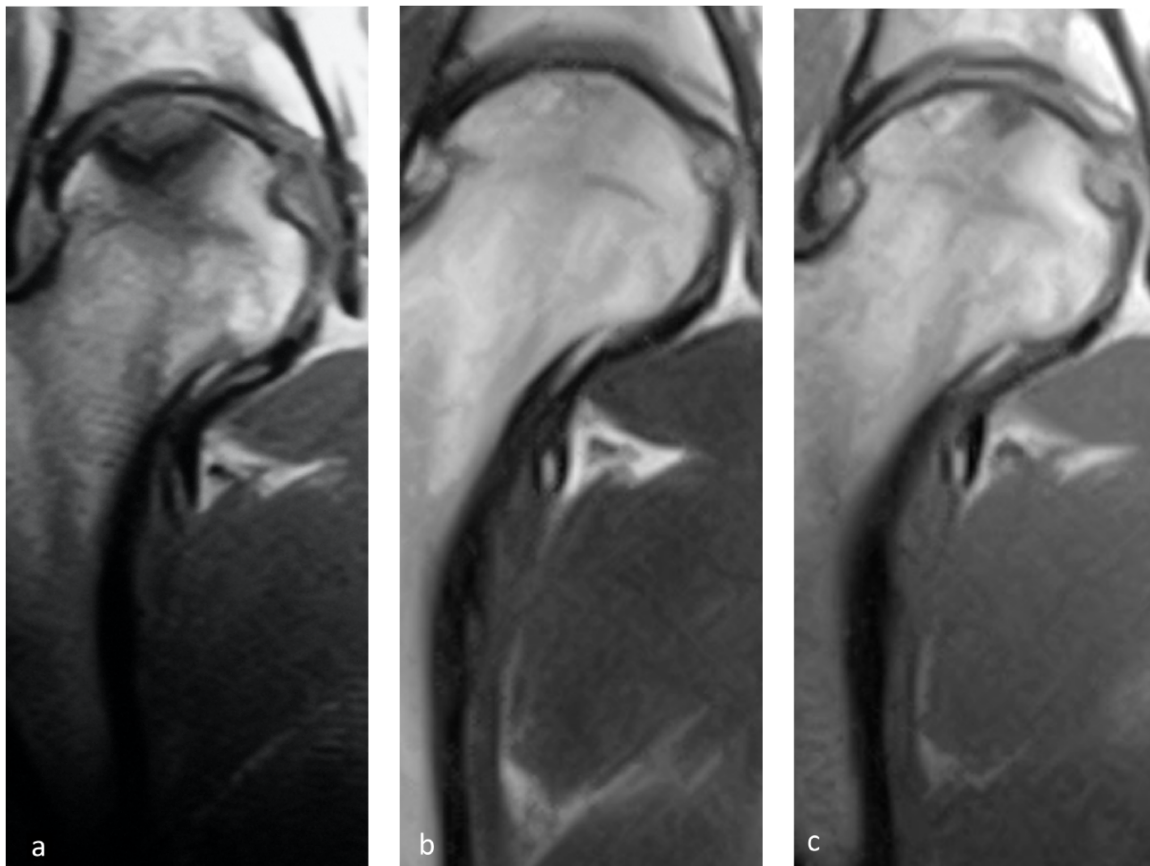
T2 MRI of a right femoral head, coronal section on the necrotic area: (a) preoperative; (b) 2 and (c) 5 years after CD and infiltration with DBM and PRF.
